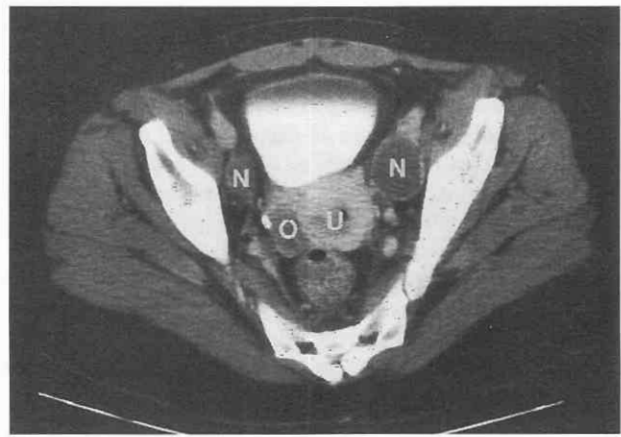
Metastatic cervical cancer. CT scan through the uterus (U) and right ovary (O) shows bilateral cystic/necrotic obturator lymph node metastases (N) from known cervical cancer.
